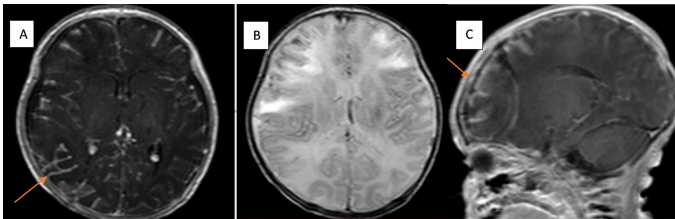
A 4-year-old boy patient with meningoencephalitis after COVID (indicated by an arrow) (A) On the post-contrast T1 Weight Imaging (T1WI) axial image cranial MRI, dural thickening and meningeal enhancement were observed at the right back parietal level. (B) On the axial Fluid Attenuation Inversion Recovery (FLAIR) image, cortical-subcortical edema is observed. (C) Increased enhancement of the meninges and dura is observed on sagittal T1WI sagittal image. COVID, coronavirus disease; MRI, magnetic resonance imaging.
